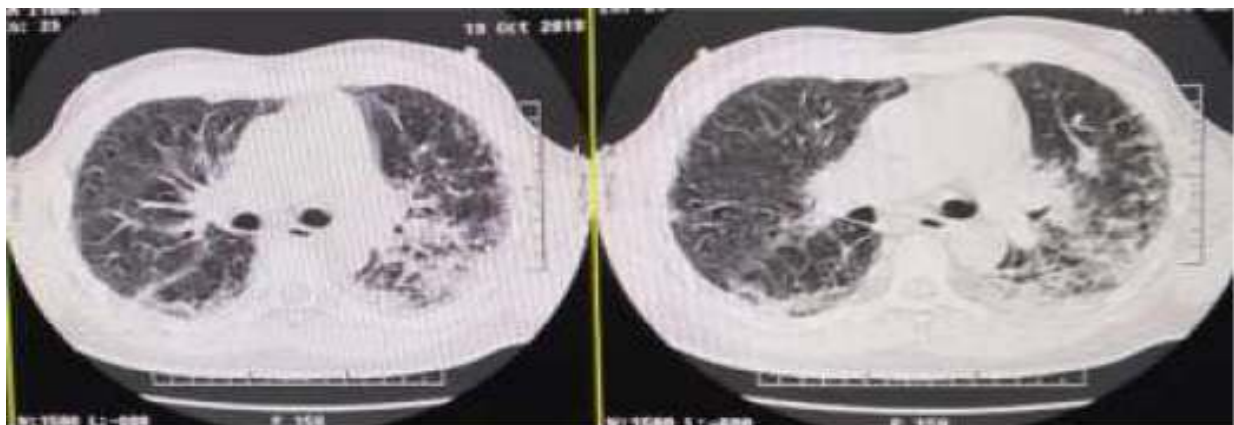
HRCT thorax showing ground glassing with interstitial thickening
